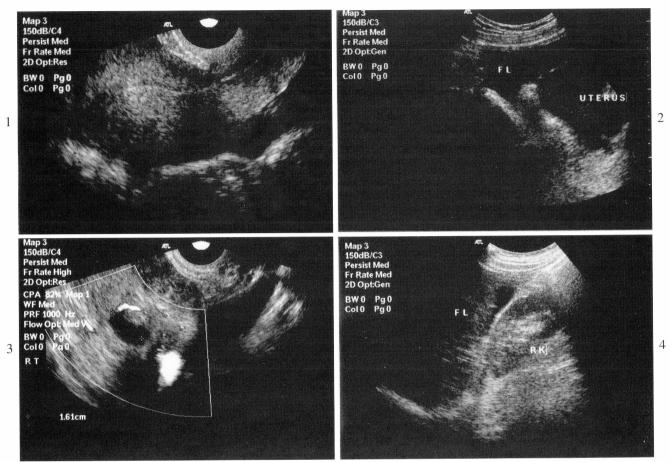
No intrauterine gestation sac was revealed by transvaginal ultrasonography (longitudinal section). Echogenic fluid fills the posterior pouch, suggesting hemorrhage.
